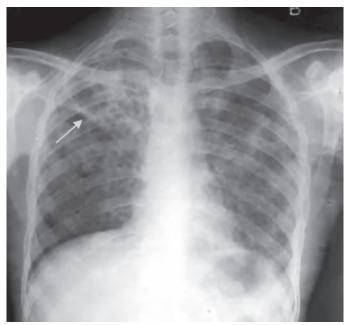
Chest radiograph: Chronic fibrocavitary tuberculosis in right upper lobe
